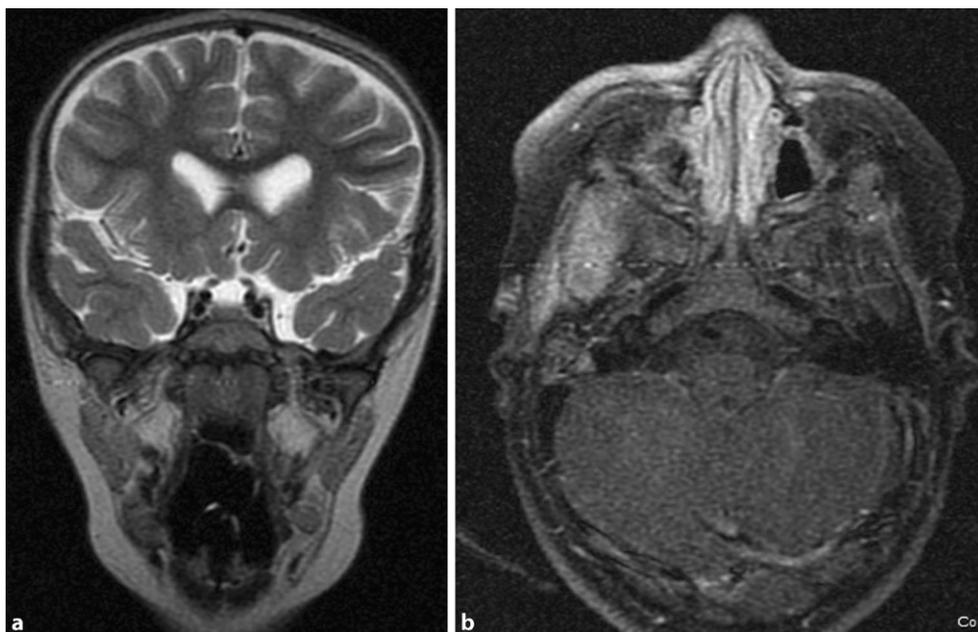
a T2-weighted magnetic resonance imaging (MRI) sequence; b T1 Fat Sat post gadolinium-based contrast MRI sequence. Imaging follow-up after completion first course of chemotherapy. Figure 6b compared to pre-treatment MRI Fig. 2d demonstrates partial response with interval decreased size in residual enhancing mass
